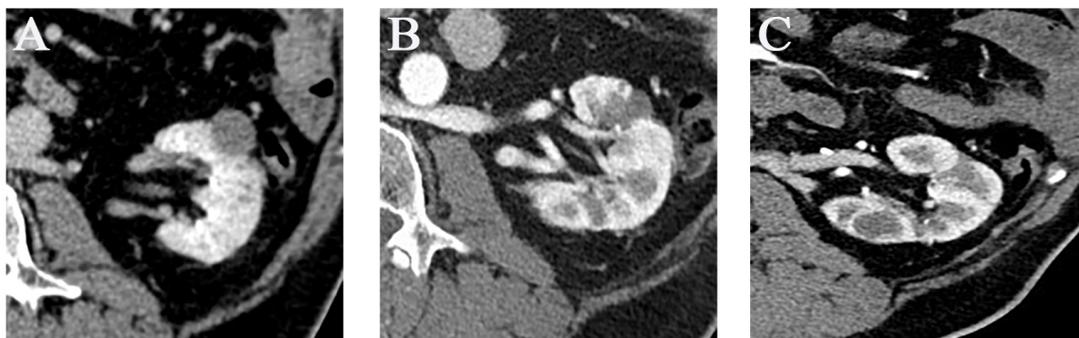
CT images of renal tumor recurrence after NSS, treated with cryoablation. A – Baseline CT demonstrating local recurrence tumor in the left kidney, B – Follow-up study 22 months after the procedure, C – Follow-up study 37 months post procedure, demonstrating gradual disappearance of the tumor.
